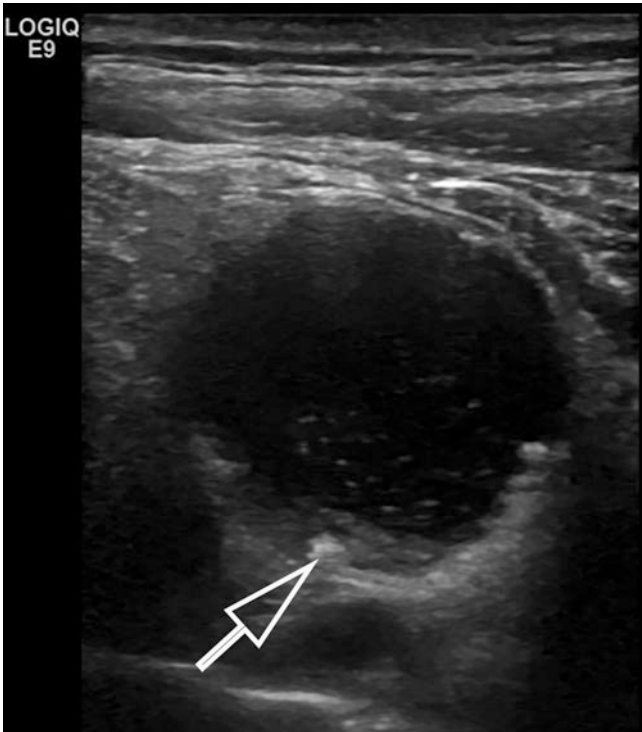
Supraclavicular lymph node metastasis of an ovarian carcinoma. The lymph node is seen on ultrasound as a nearly anechoic (cystic) rounded lesion with sharp margins and calcified edges (arrow)
